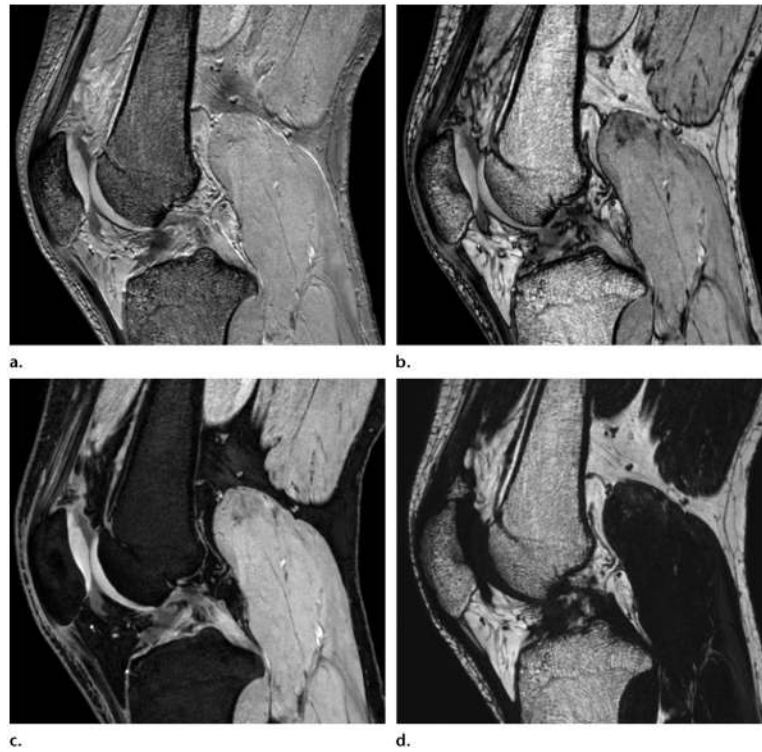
Multipoint (four-point) high-resolution 3D ($0.5 \times 0.5 \times 1.5 \text{ mm}^3$) Dixon (Philips, Best, the Netherlands) MR images (TR, 10.4 msec) obtained in phase (a), out of phase (b), with water suppression (c), and with fat only (d) show a normal knee.
